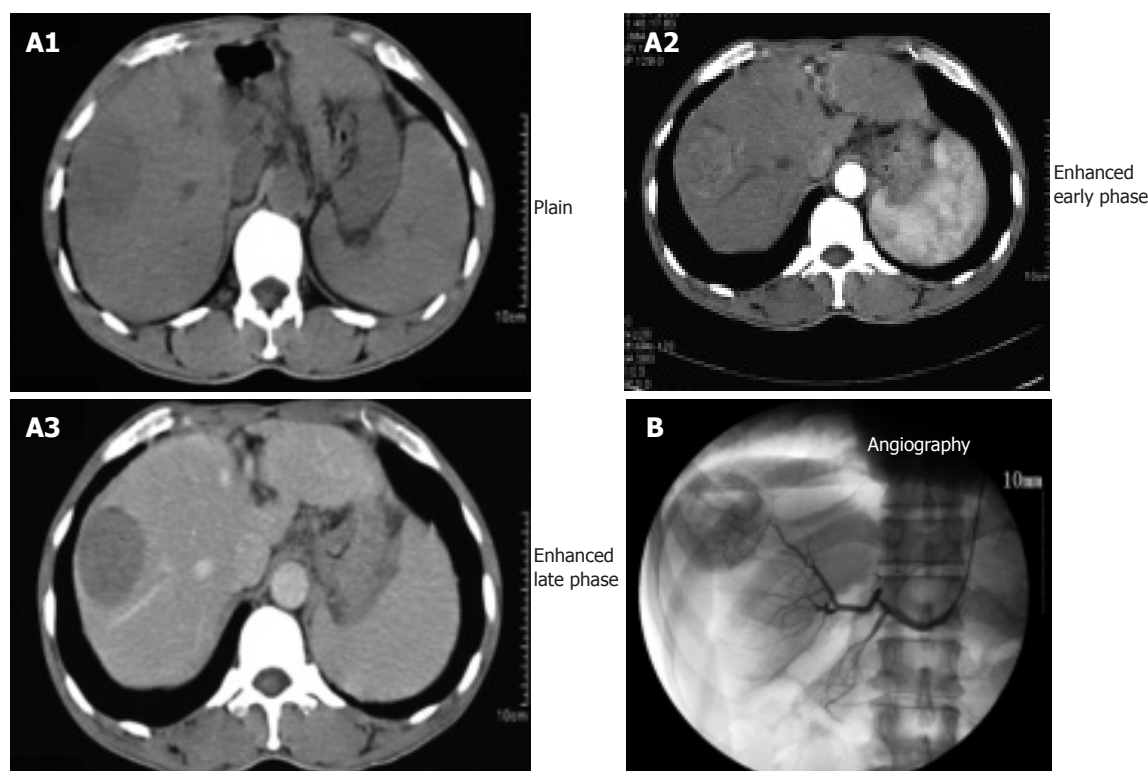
Helical dynamic abdominal CT revealing a liver tumor with a maximum diameter of 5.2 cm in segment 8 (A) and abdominal angiography showing hypervascularity in it (B).
